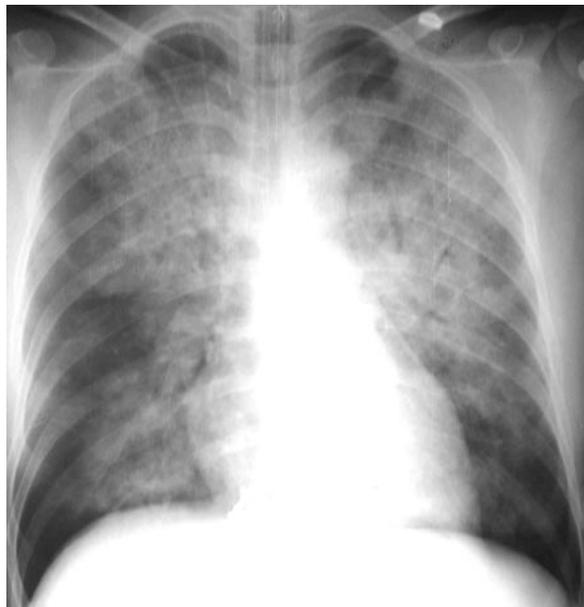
Cardiogenic pulmonary edema in a 36-year-old woman who presented with shortness of breath and chest pain after smoking crack cocaine. Initial chest radiograph shows extensive bilateral heterogeneous central and parahilar opacities.
